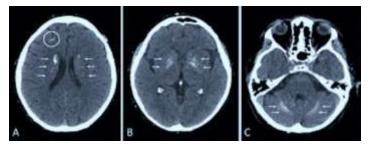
CT-scan of the patient showing calcifications of the basal ganglia
